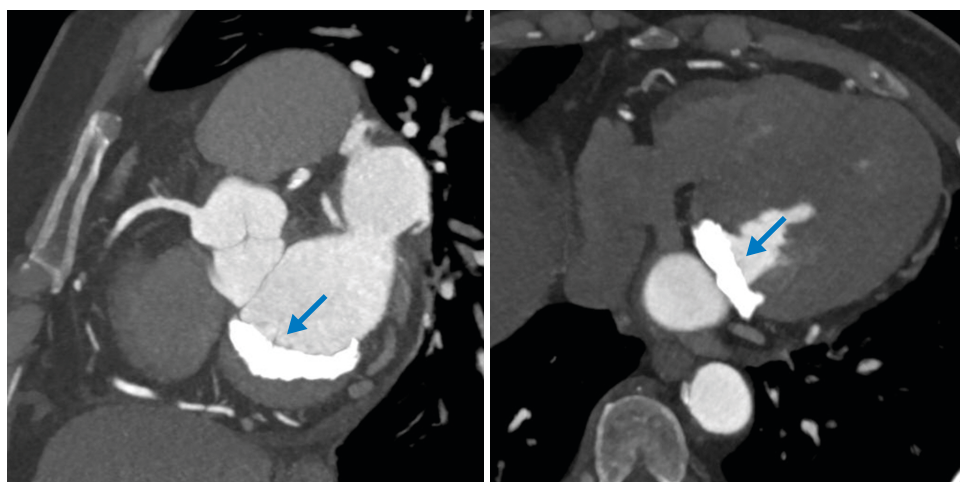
Severe calcification of the mitral valve was found on coronary-computed tomography (blue arrow: mitral annular calcification).
